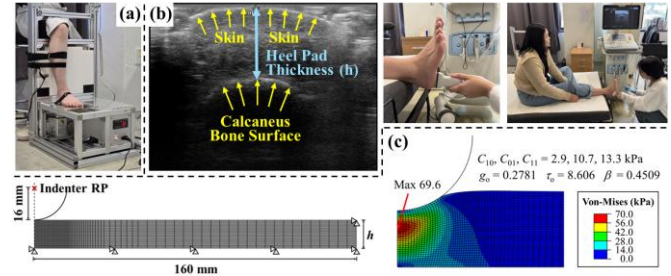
(a) Indentation test setup; (b) Ultrasonography for heel pad thickness measurement; (c) FEA model showing 2D geometry, von Mises stress distribution, and material parameters.
